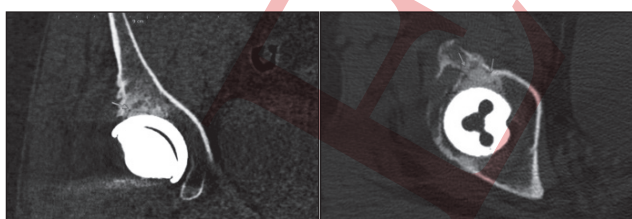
Multi-slice computed tomography of the right hip joint and osteointegration of materials based on TCP and HA [10].
